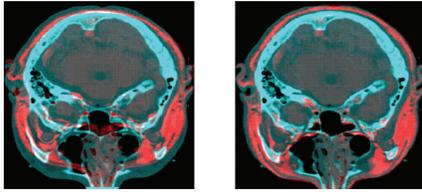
CT (cyan) and original MRI (red). (a) unregistered, (b) registered.
